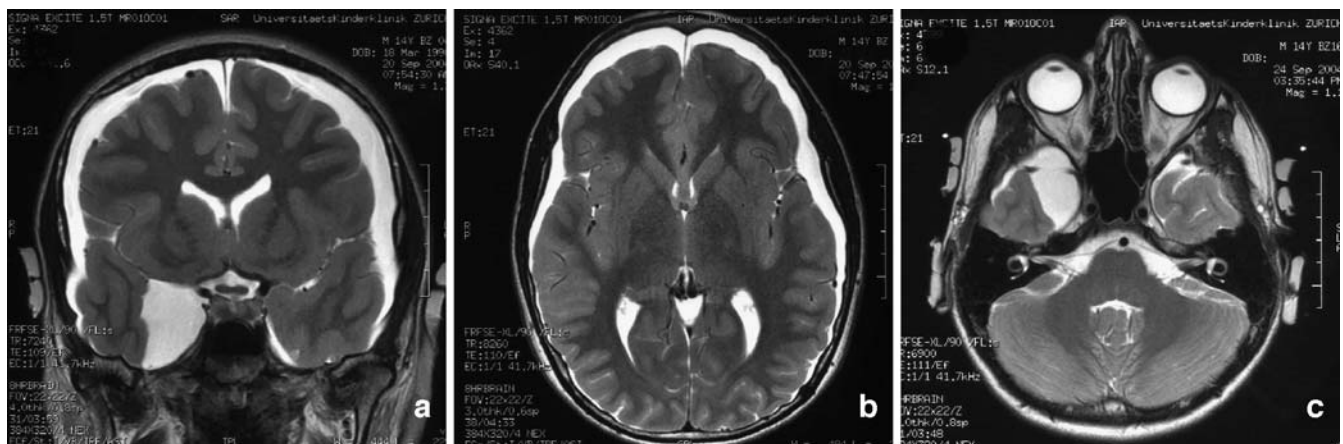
Serial axial (a, c) and coronal (b) T2-weighted fast spin-echo MRI. Initial axial (a) and coronal (b) MRIs show bilateral T2-CSF isointense subdural hygromas along both cerebral hemispheres, as well as a small right middle cranial fossa arachnoid cyst. Follow-up axial MRIs (c) showed a discrete wider left parapontine cistern compared to the contralateral side. No brainstem pathology is seen
